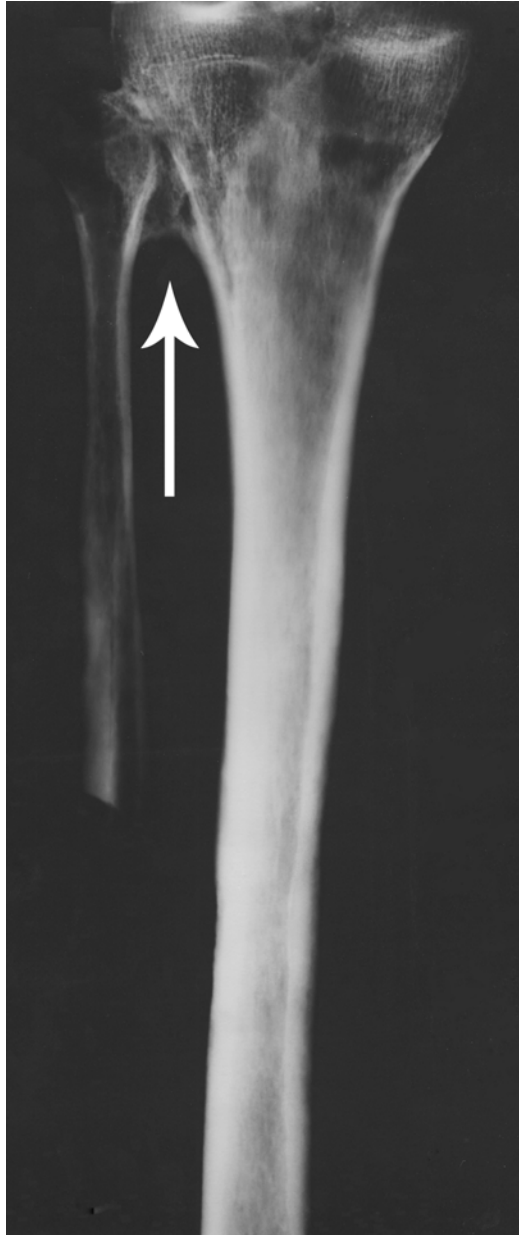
X-ray of the tibiofibular synostosis.
